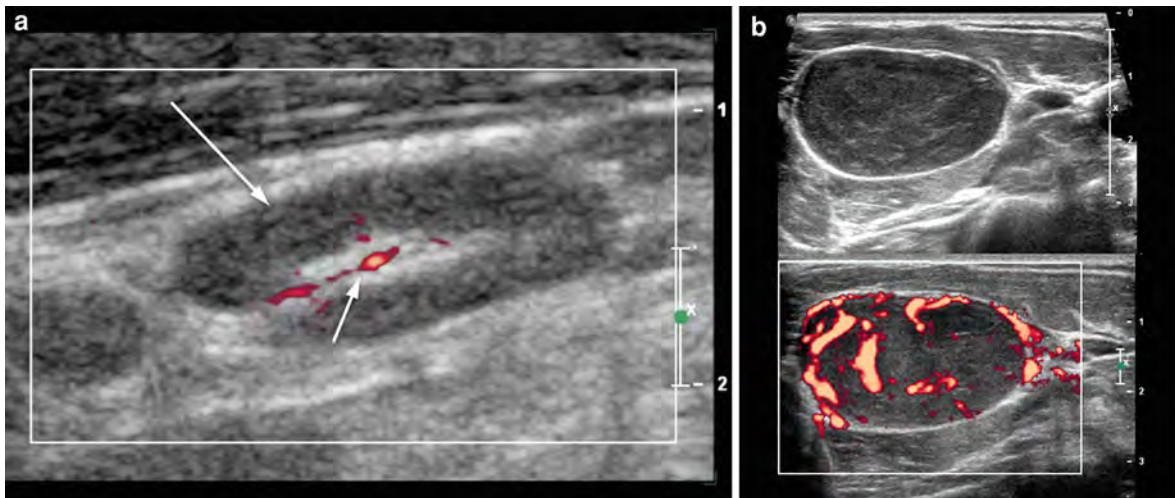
a Grey scale US of a normal lymph node (*long arrow*) showing the peripheral cortex (*long arrow*) central echogenic hilum (*short arrow*) with hilar vascularity. b Grey scale US (*top*) with corresponding grey scale and power Doppler US
